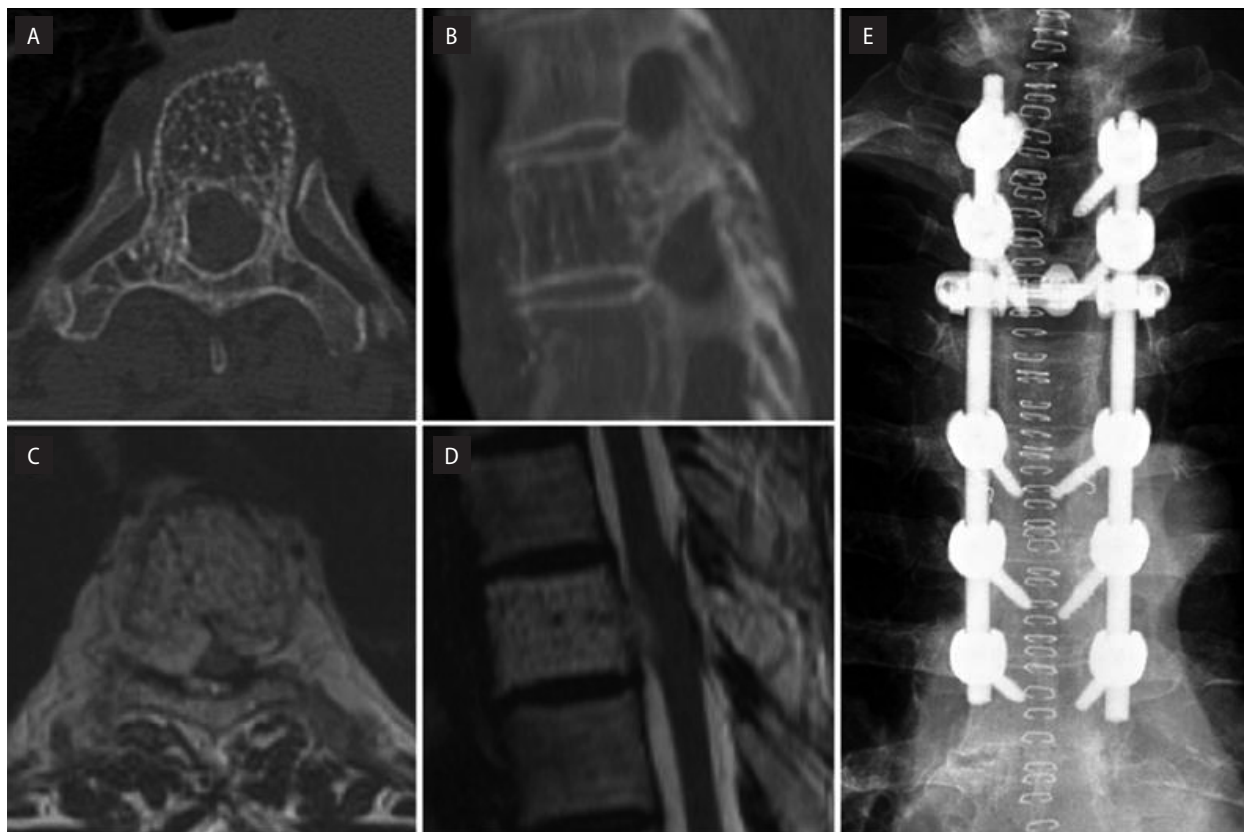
Images obtained in Case 2 which involved a 63-year-old woman who presented with myelopathy. A. Axial computed tomography (CT) image demonstrating an aggressive vertebral hemangioma at T-4 with a characteristic honeycomb pattern that expands the cortex and involves the entire vertebral body and both pedicles and extends into the posterior elements. B. Sagittal CT image showing a corduroy pattern characteristic of vertebral hemangiomas. CD. Axial (C) and sagittal (D) T2-weighted MR images showing epidural spread of disease. This patient underwent a decompressive laminectomy and instrumented fusion for subtotal resection of the tumor followed by a course of radiation therapy. E. Postoperative anteroposterior radiograph [17]
